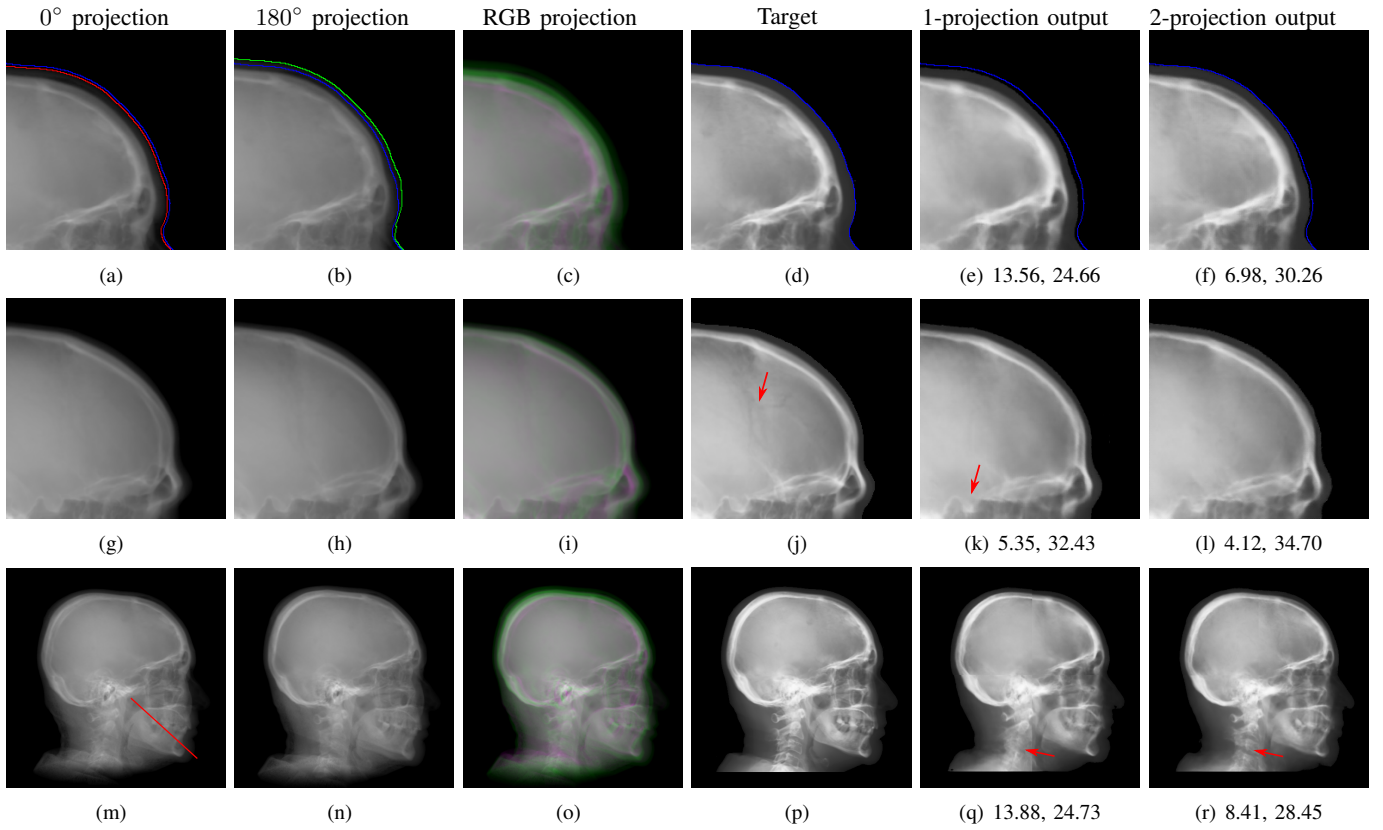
Synthetic cephalogram examples from 2D CBCT projections. The top two rows are two patches respectively while the bottom row is a complete stitched cephalogram. In the top row, the blue curve is the outline of the target patch, while the red and green curves are the outlines for the 0° and 180° projections, respectively. In the middle row, the cranial sutures indicated by the arrow in (j) are not visible in (k) nor in (l); the sella turcica indicated by the arrow in (k) is distorted. In the bottom row, the vertebrae indicated by the arrow in (r) are more accurate than those in (q). The line in (m) mark the position for line profiles in Fig. 10. For the 1-projection output and 2-projection output, the RMSE (left) and PSNR (right) values w. r. t. the target are displayed in the corresponding subcaptions.
